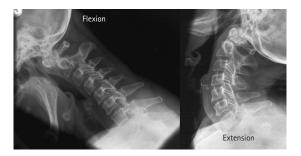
Examples of cervical spine flexion and extension radiographs.
